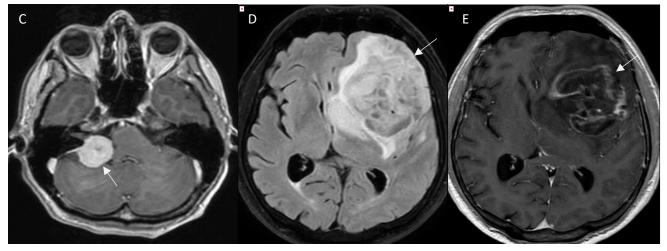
C - MRI, T1 weighted image after contrast adminitration, meningioma in posterior cranial fossa near petrous part of temporal bone (white arrow), homogenoust contrast enhancement, enhancement of adjacent dura mater
